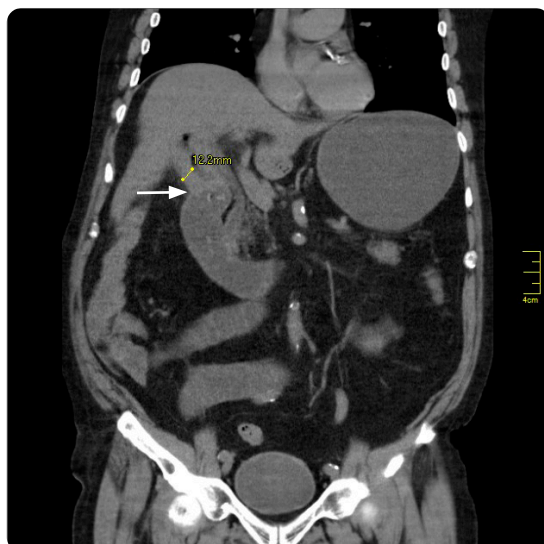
Abdominal CT, coronal image. Marked inflammatory changes of the gallbladder with thickening of the wall (12.2 mm). Loss of the cleavage plane between the gallbladder and the second portion of the duodenum due to the presence of duodeno-biliary fistula (blue arrow).
